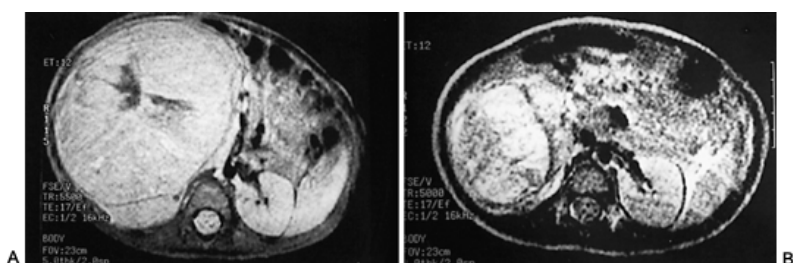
A: Magnetic resonance imaging scan of a large inoperable Wilms' tumor. B: After 6 weeks of chemotherapy, the same tumor has decreased in size dramatically.
